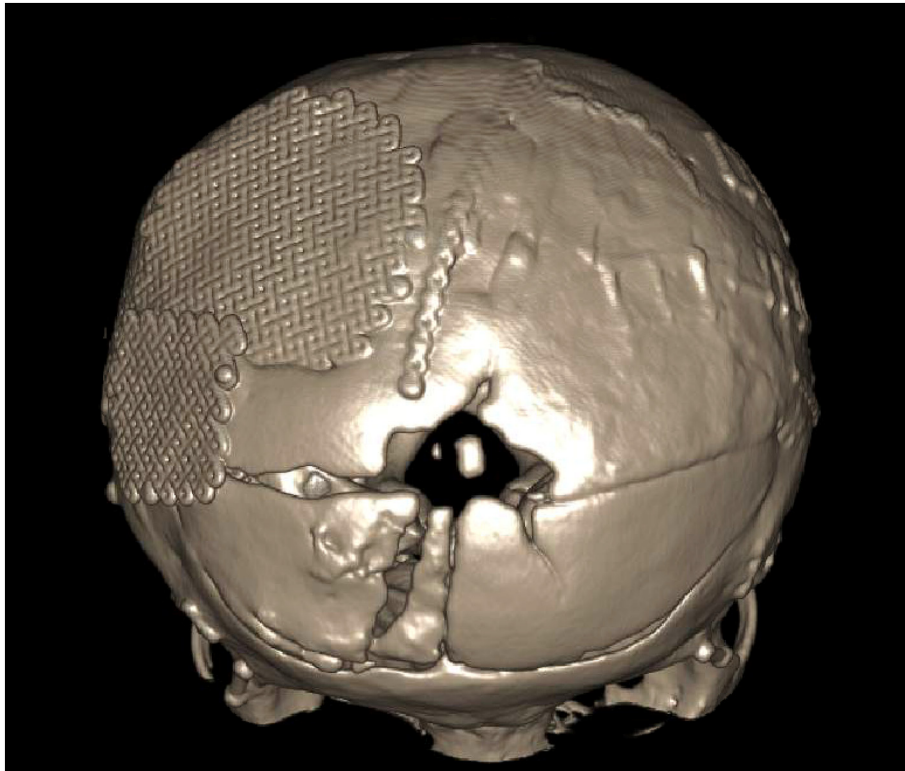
Patient 1-3 dimensional CT scan reconstruction demonstrating titanium implant coverage.
